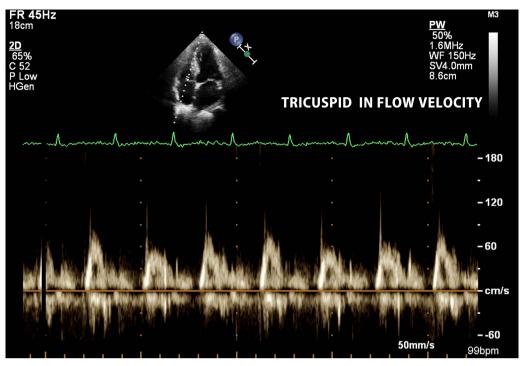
Echocardiography showing tricuspid inflow velocity with no significant respiratory inflow variation.
